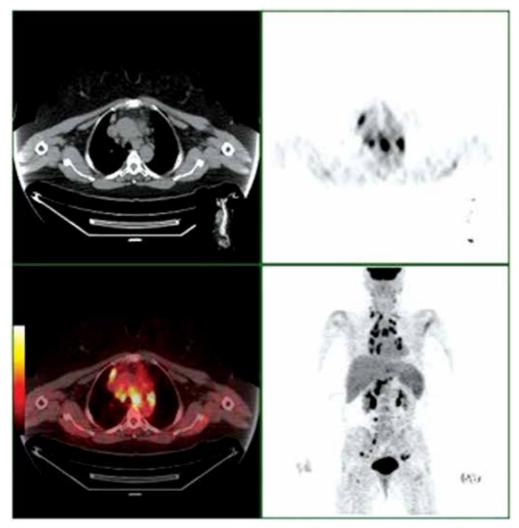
A 37-year-old female with mediastinal lymphadenopathy on chest radiograph (not shown). An FDG-PET/CT shows extensive FDG-avid hilar, mediastinal, intrabdominal and inguinal lymphadenopathy. Biopsy confirmed the diagnosis of sarcoidosis. (Courtesy of Dr. McGrath, SUNY Upstate Medical University, Syracuse, New York, USA)
